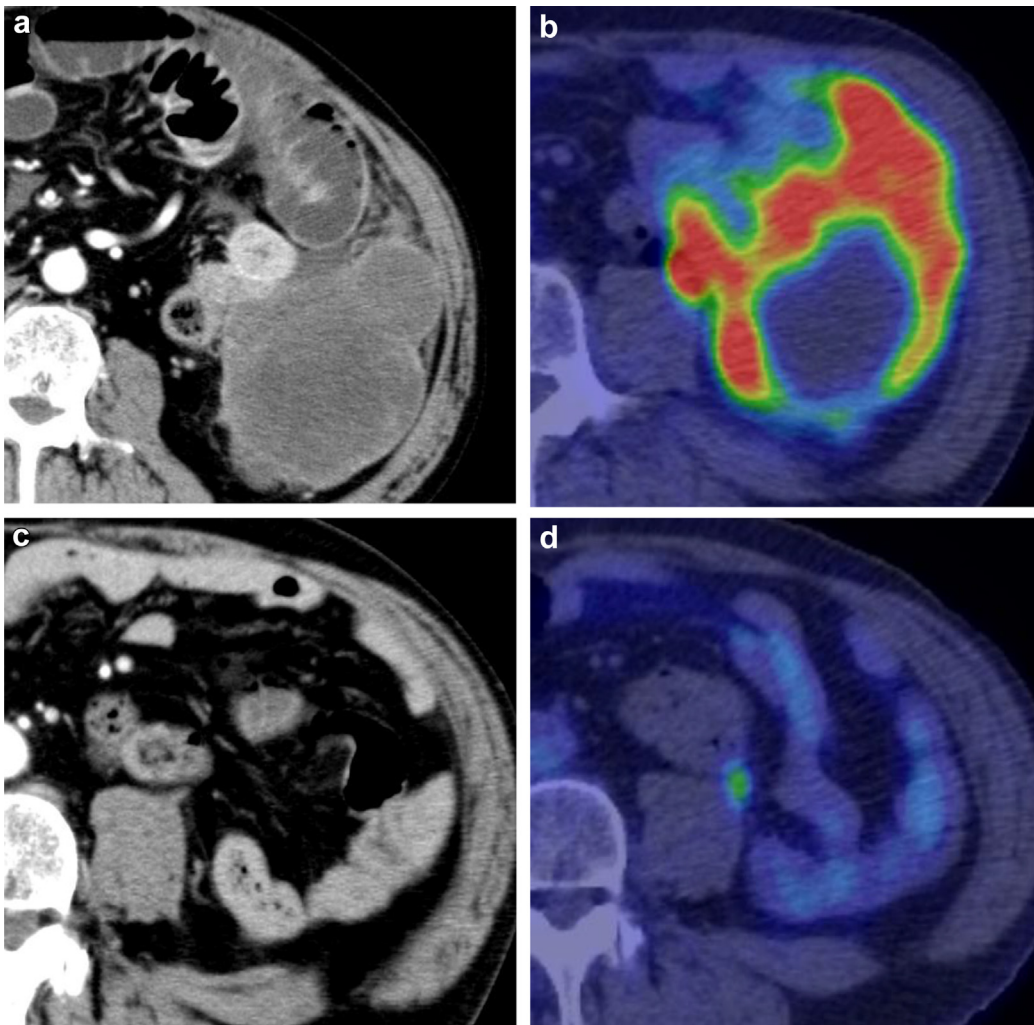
(a) Computed tomography of the abdomen showing a 1-cm mass adjacent to the descending colon and an intestinal obstruction. (b) $2\text{-}^{18}\text{F}$ fluorodeoxy-D-glucose positron emission tomography (FDG-PET) of the abdomen. (c) After six cycles showing complete response. (d) $2\text{-}^{18}\text{F}$ fluorodeoxy-D-glucose positron emission tomography (FDG-PET) of the abdomen after six cycles with absence of a positive lesion.
